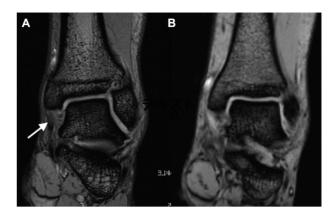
Magnetic resonance imaging (gradient echo images). (A) Normal posterior tibiotalar ligament (PTTL): the PTTL showed a striated appearance (arrow). (B) Injury of the PTTL: the PTTL did not appear striated, and high-intensity signal changes were observed.
